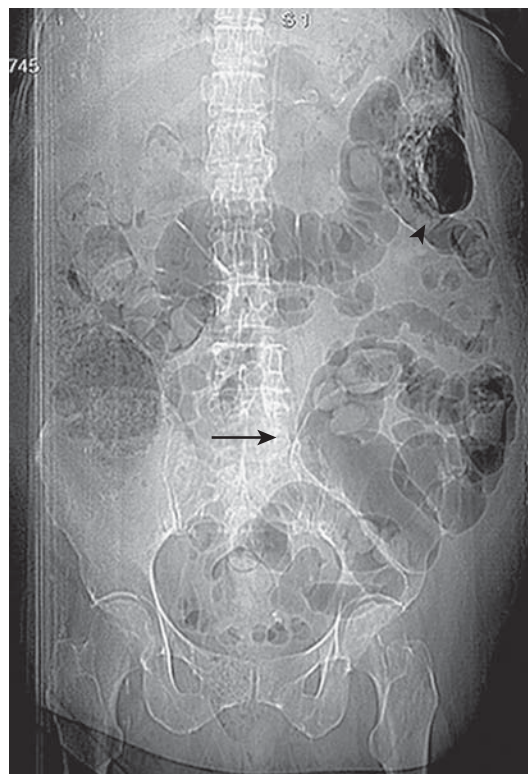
Mesenteric ischemia and spleen infarction. Abdominal radiograph shows a colonic dilation (arrow) that is especially marked at distal segments. Furthermore, extracolonic air collections are visible at the spleen level (arrowhead) in the upper left quadrant. Bowel dilation is evident without the finding of bowel obstruction.
